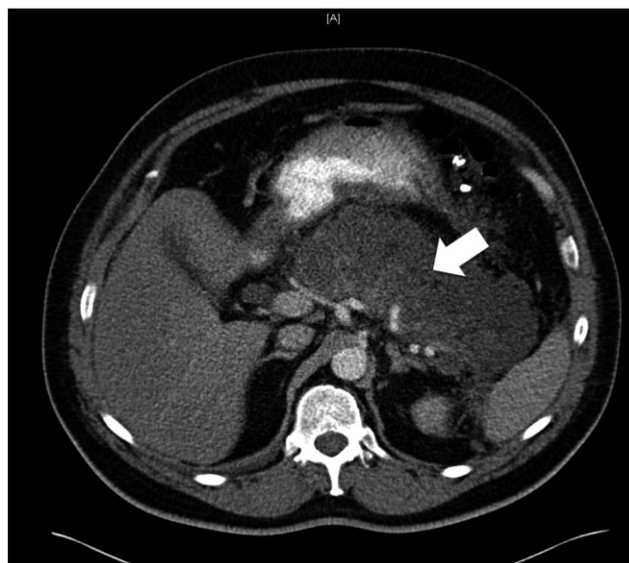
Contrast-enhanced CT scan from the same patient on hospital day 5 demonstrating extensive pancreatic necrosis (arrow).
